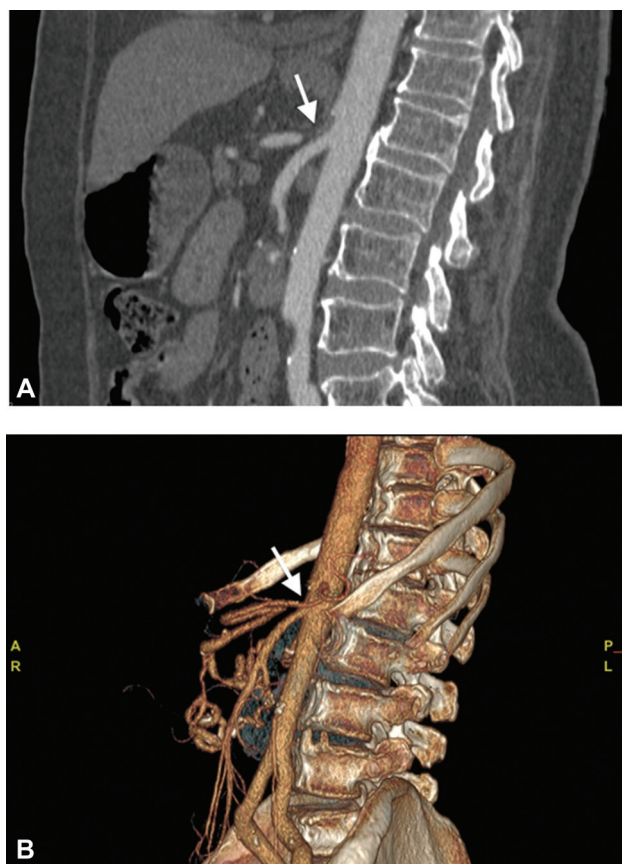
Sagittal maximum-intensity projection (A) and volume-rendered (B) computed tomographic images showing severe stenosis of the celiac trunk orifice (arrow).
